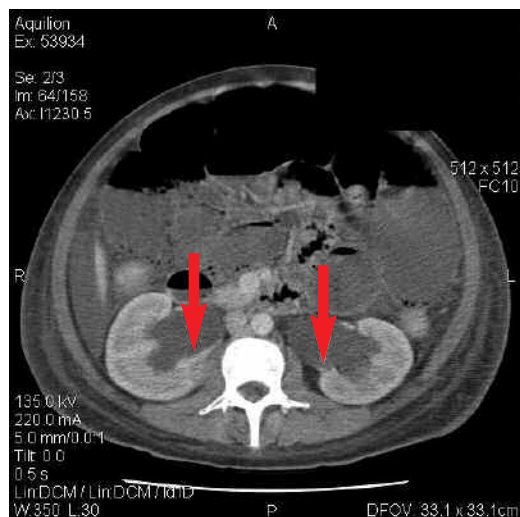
Abdominal computed tomography revealing bilateral ureterohydronephrosis.
